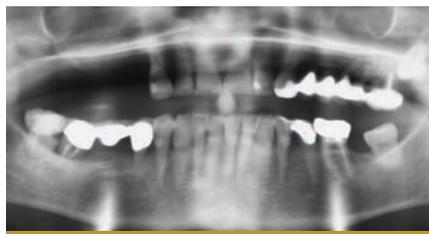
Case 1: Preoperative panoramic x-ray showing the partially edentulous left maxilla of a 67-year-old female patient.
